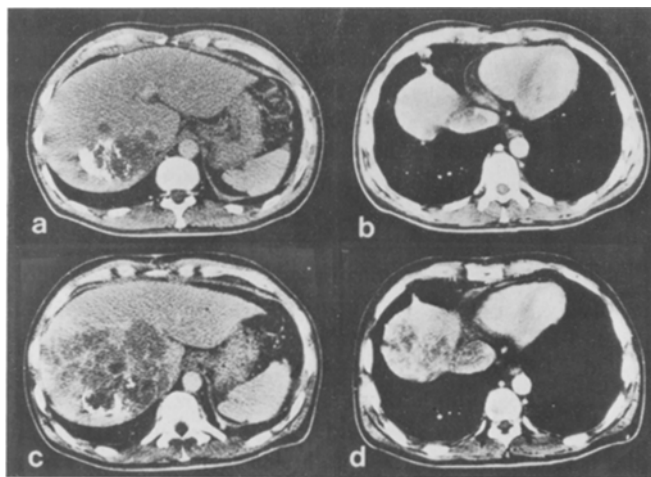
CT images obtained a, b just prior to open-heart surgery and c, d 1 month later in case 2. a A large hypodense nodule with daughter nodules is located in segment 7. Significant disappearance of deposited Lipiodol is noted. b Tumor thrombus in the inferior vena cava is clearly shown as a hypodense mass. c Rapid expansion of the liver tumor during 1 month is evidenced by this CT image in comparison with a. d Tumor thrombus almost completely occludes the inferior vena cava, and expanding liver tumors invade segment 8
